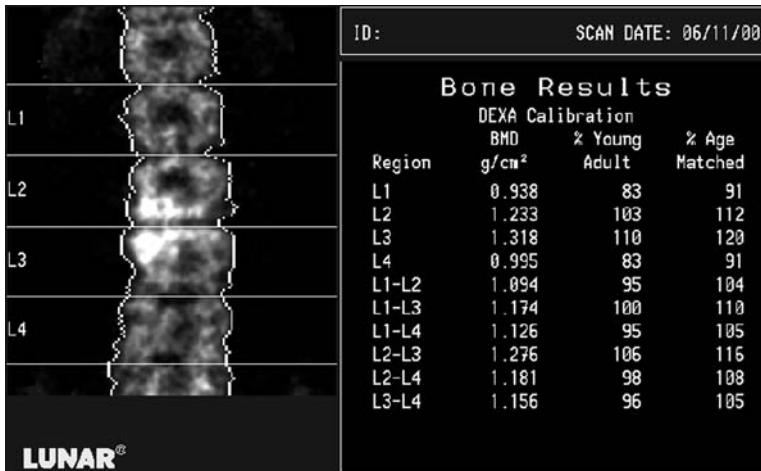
A DXA PA spine study acquired on the Lunar DPX. The image dramatically suggests the sclerotic process seen on the X-ray in Fig. 2-12. There is a marked increase in the BMD at L2 and L3 compared to L1 and L4.
